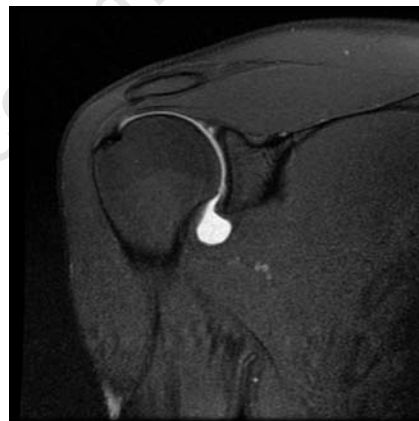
Coronal MRI image of the shoulder showing extravasation of the contrast media into the type II SLAP tear.
